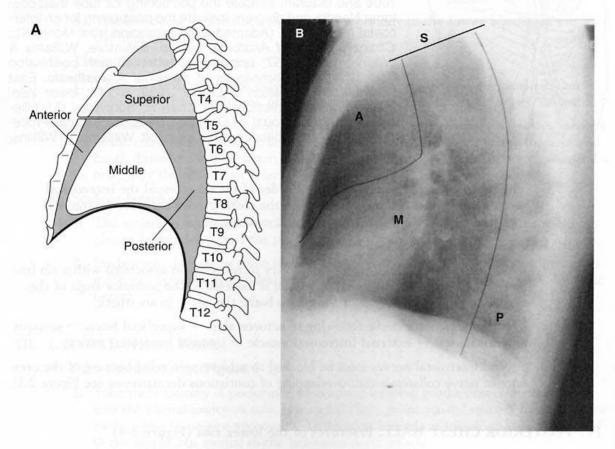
Mediastinum. (A) Superior, anterior, middle, and posterior divisions of the mediastinum. (B) Lateral radiograph demarcating the superior (S), anterior (A), middle (M), and posterior (P) divisions of the mediastinum. (B adapted with permission from Freundlich IM, Bragg DG: A Radiologic Approach to Diseases of the Chest, 2nd ed. Baltimore, Williams & Wilkins, 1997, p 610.)
